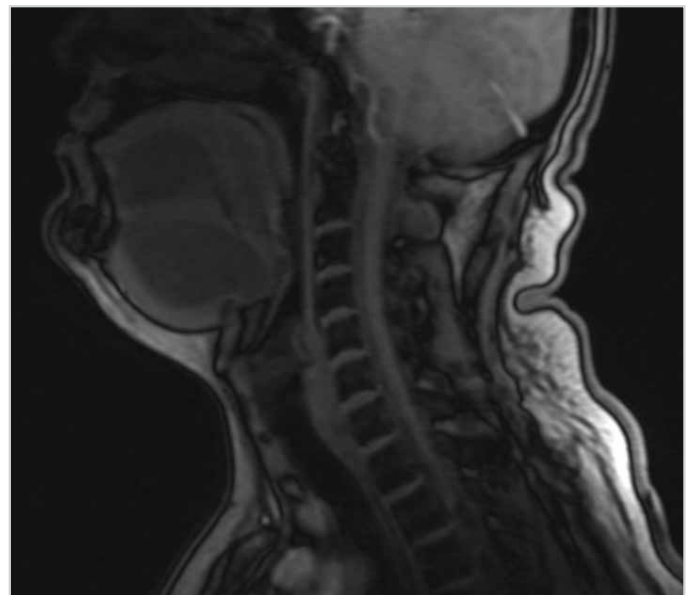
MRI of the ranula extending posteriorly
